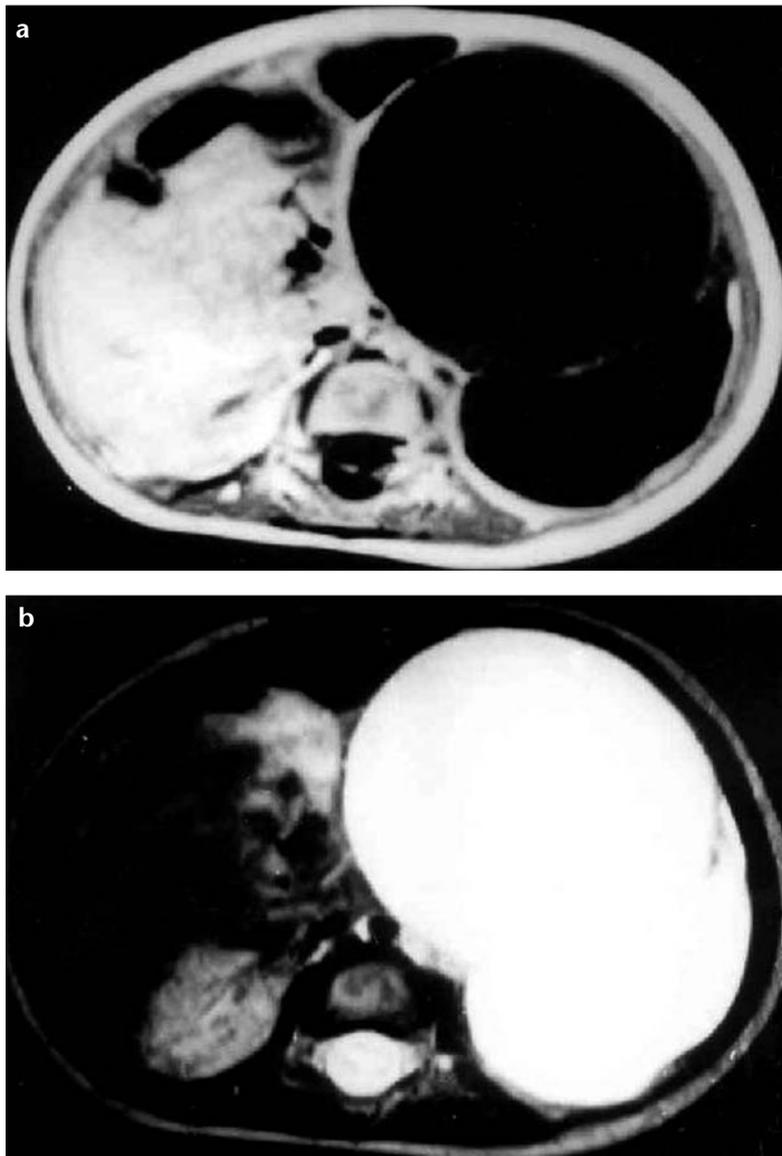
a, b. Transverse T1- (a) and T2-weighted (b) MR images show a lobulated mass in the left upper quadrant of the abdomen, hypointense on T1- and hyperintense on T2-weighted sequences.
